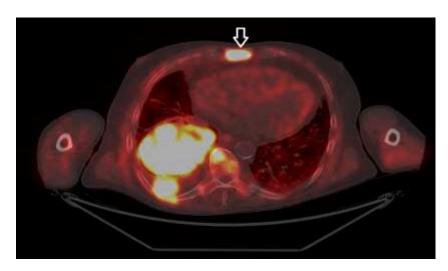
Increased FCH uptake in the body of the sternum (SUVmax 12.0) — highly suspicious for a metastatic lesion from pulmonary carcinoid.
